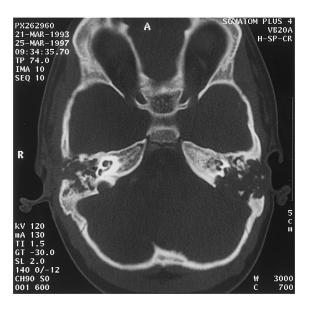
Transverse CT scan with bone windows. Bilateral destruction of the petrous temporal bones with opacification of both middle ear cavities and the external auditory canal on the left.
